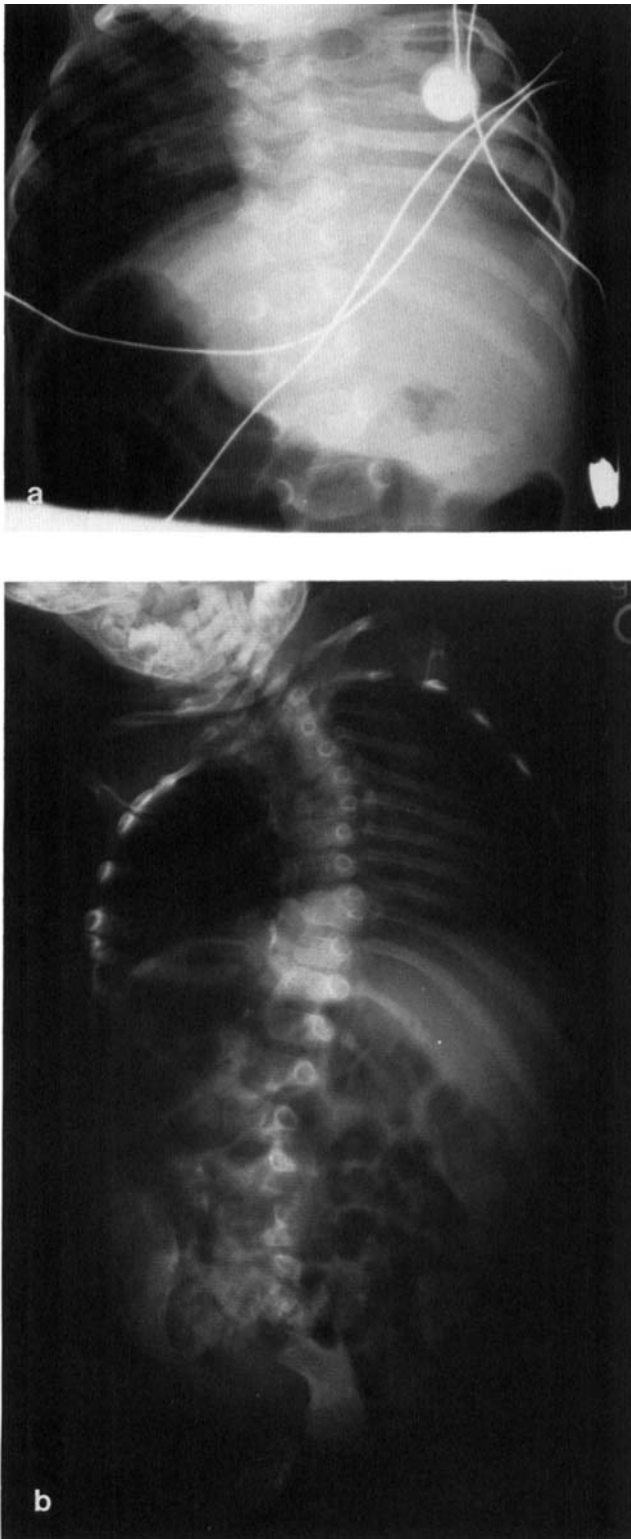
Disparate involvement in monozygotic female twins. a: Anteroposterior view of the chest film of patient 5. Only eight ribs are present on the left side with rib fusions between the first four ribs. This twin died at 14 months. b: Anteroposterior view of the radiographic film of the thorax of patient 6. The right hemithorax is more severely affected and deformed than the normal appearing left hemithorax. This twin survived.
